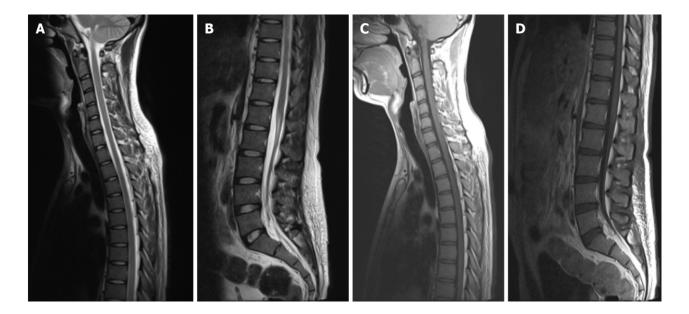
Magnetic resonance imaging scan of spinal cord one week after methylprednisolone treatment. A: Sagittal T2WI sequence of the cervical spine shows a reduced range of long T2 signals in C3-C6 and T7-T8 segments compared with the previous one (arrows); B: Sagittal T2WI sequence of the lumbar spine: A reduced range of long T2 signals in T7-T8 segments compared with the previous one (arrows); C: Sagittal enhancement sequence of the cervical spine: No abnormal enhancement was seen; D: Sagittal enhancement sequence of the lumbar spine: No abnormal enhancement was seen.
